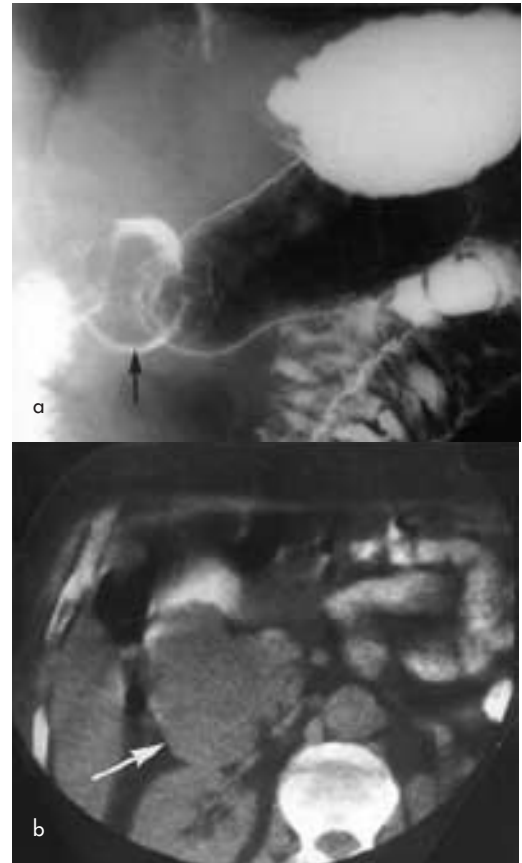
Metastasis to duodenum. a. A barium examination shows a large filling defect occupying the duodenal cap (arrow). b. Computed tomography shows a large irregular mass invading the duodenum. This proved to be a metastatic liposarcoma; the patient had previously had a primary liposarcoma resected from the thigh.
